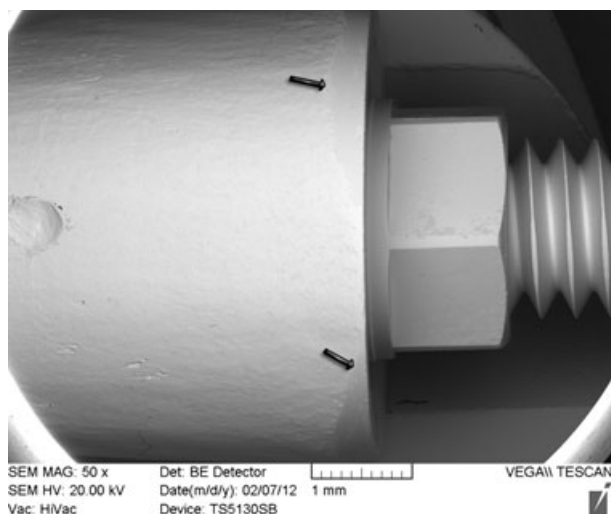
Test group 1 abutment (ultrasonic cleaning): no pollution is revealed on the abutment surface, connection and screw ($\times 50$). Arrows highlight finishing line.
